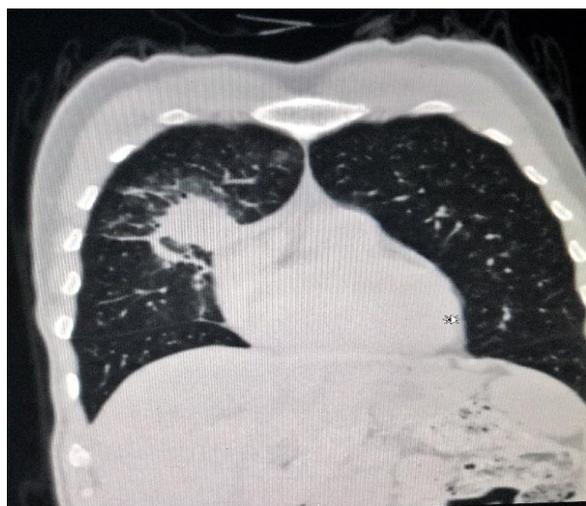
CT chest with a patch of consolidation in the medial segment of right middle lobe
